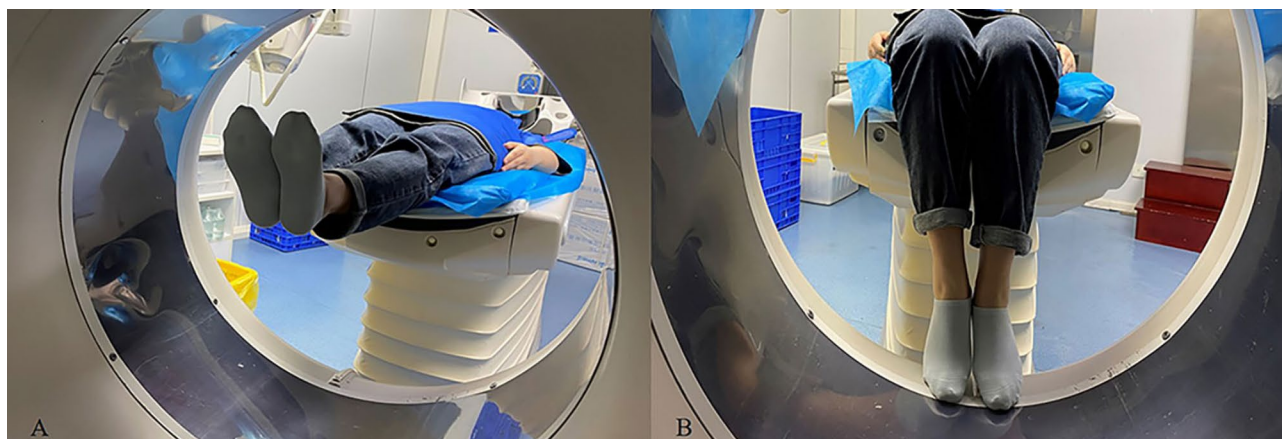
Position of the subject during 4D-CT scan. The subject is in a supine position and the subject is asked to fully extend and flex both legs in approximately 10 s
